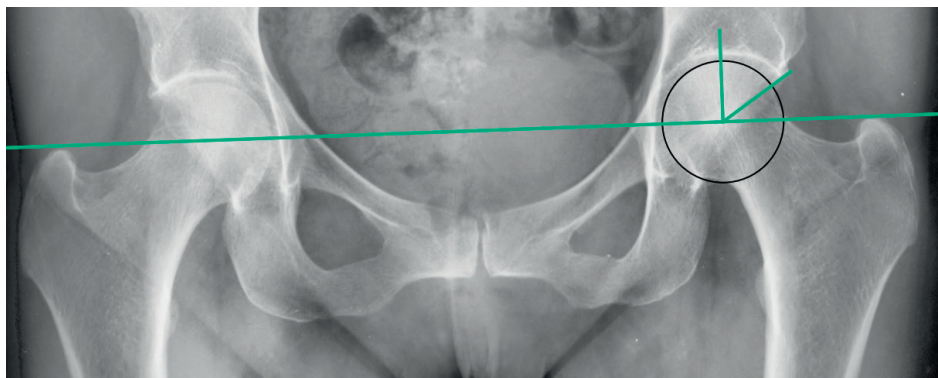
The lateral center edge angle (LCEA) is measured on an AP pelvic radiograph. The LCEA was constructed according to the following steps. A horizontal reference line is constructed to correct for pelvic tilt in the radiograph, and is based on the average of 4 lines, between 1) both femoral head centers, 2) the most cranial points of the foramen obturator, 3) the most caudal point of the ischial tuberosity and 4) the most caudal point of the pelvic teardrop. To determine the center of the femoral head, a best fitting circle is drawn around the femoral head based on the SSM points. The LCEA is then formed by two lines drawn from the center of the best fitting circle. The first line is drawn vertically through the center of the femoral head, perpendicular to the horizontal reference line. The second line is drawn from the center of the best fitting circle to the most lateral bony point of the acetabulum.
